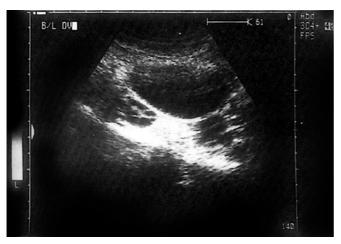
Polycystic ovary seen on ultrasound
